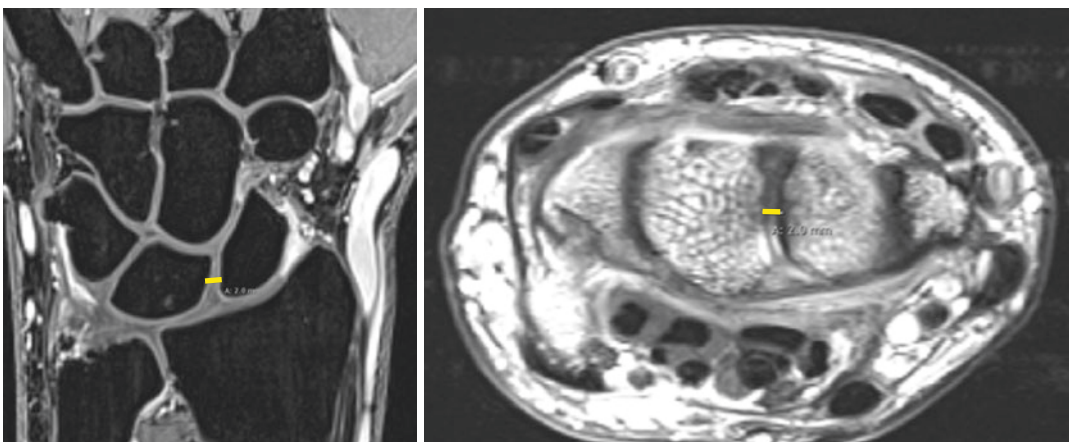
Scapholunate distance measurement on MRI at the midpoint of the joint in coronal and axial planes
